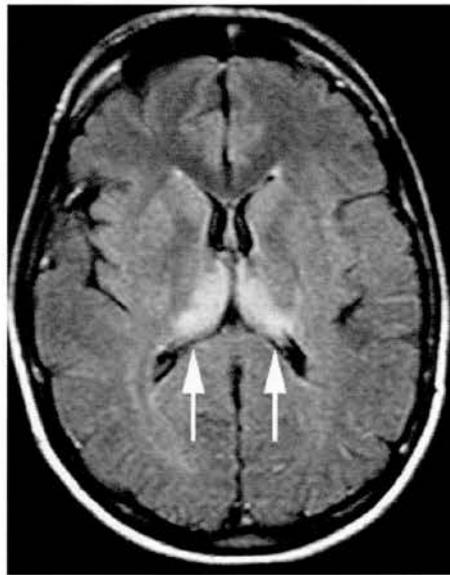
The Pulvinar sign on MRI in vCJD (FLAIR sequence) (14)
